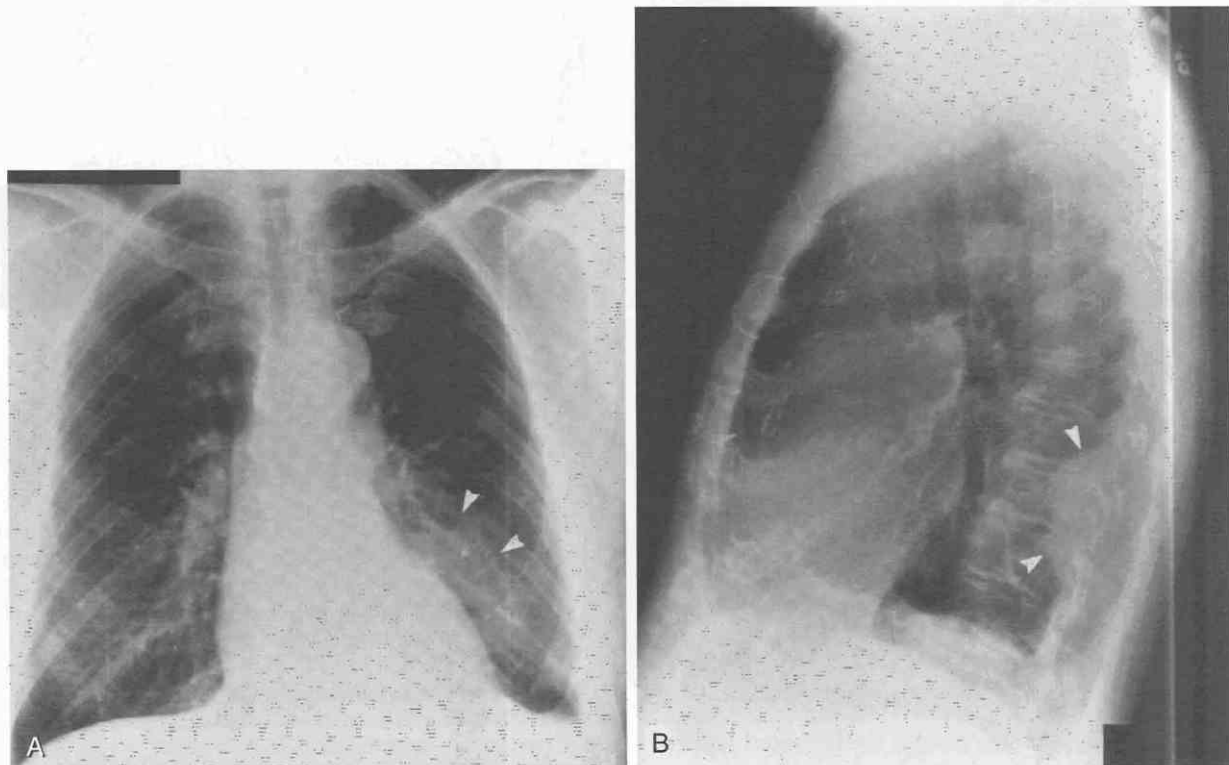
CT features of rounded atelectasis. A and B, Chest film shows ill-defined mass in the posterior left lower lobe (arrowheads). The patient underwent coronary bypass surgery, and now evidence of pleural thickening with blunting of the left costophrenic angle can be seen.
